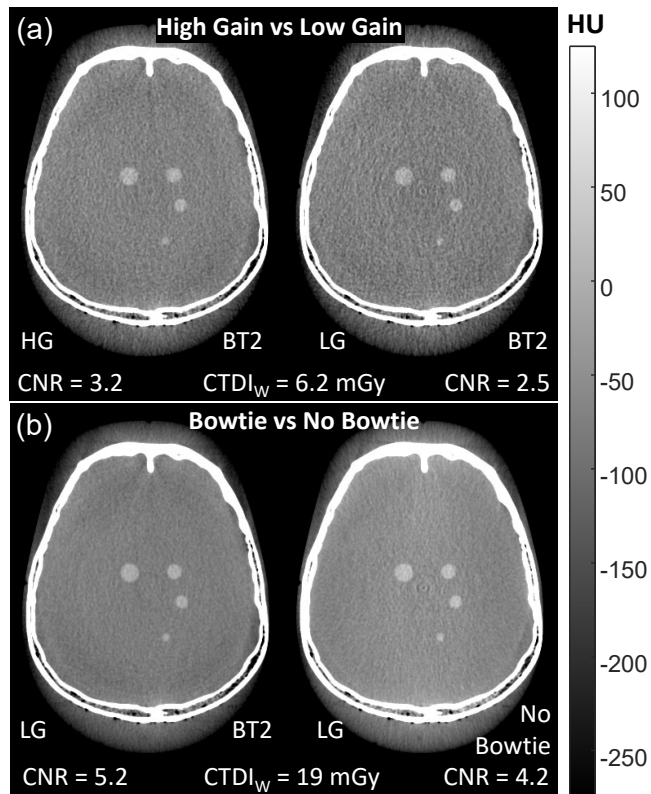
CBCT image quality using HG and a bowtie filter. (a) The HG image acquired with BT2 shows a 28% improvement in CNR compared to (b) the LG image with bowtie. (c) Dose-matched ( $CTDI_w = 19$  mGy) images with and (d) without a bowtie show a 24% improvement in CNR near the center of the head with use of a bowtie filter.
